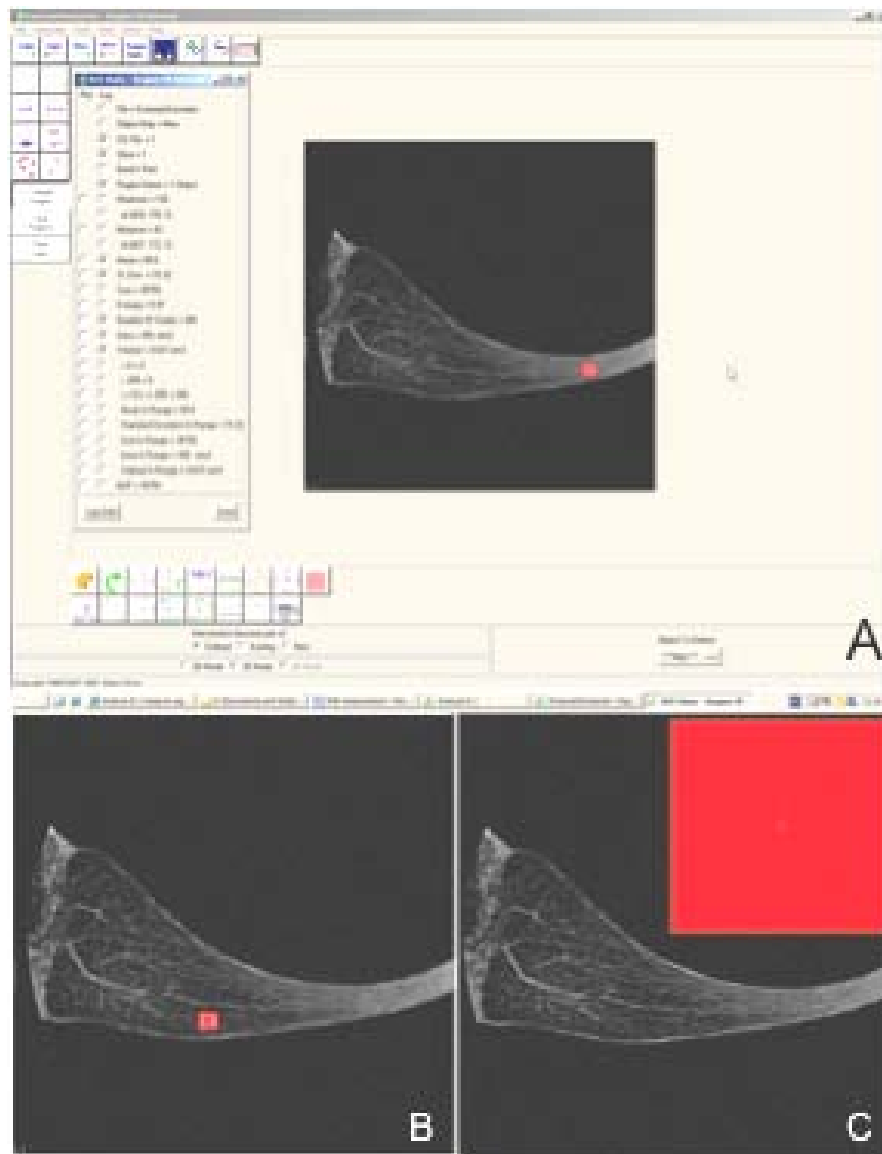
An example of SNR and ReCon measurement of meniscal MR images using the Analyze™ software. The red boxes show the region selection.
